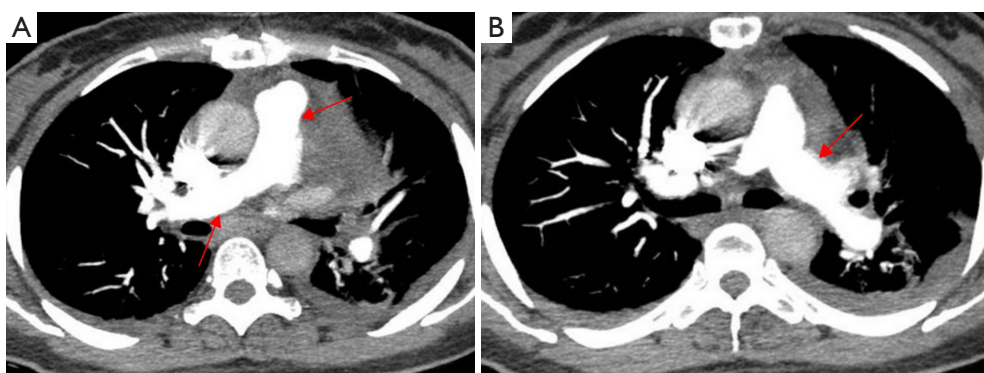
Computed tomography pulmonary angiography shows no filling defects in the main, right and left pulmonary arteries at 1 month after surgery (red arrows) (A,B).
